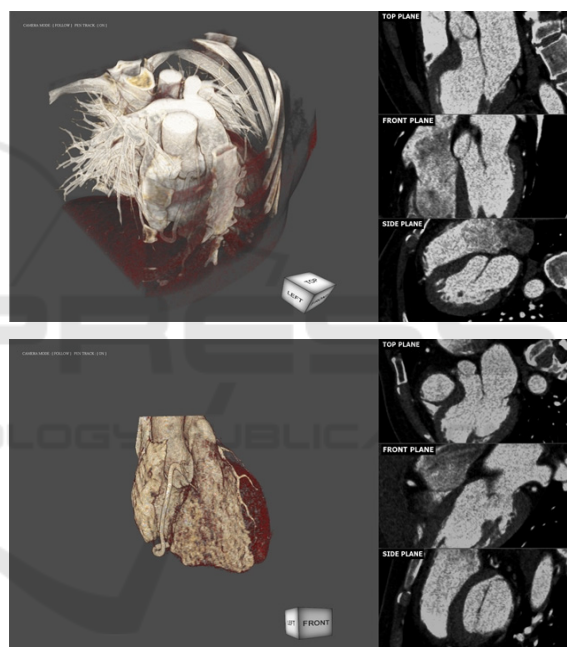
3D cardiac CT navigator S/W proto. Original CT volume is rendered without any segmentation (up) and whole segmentation (down).
